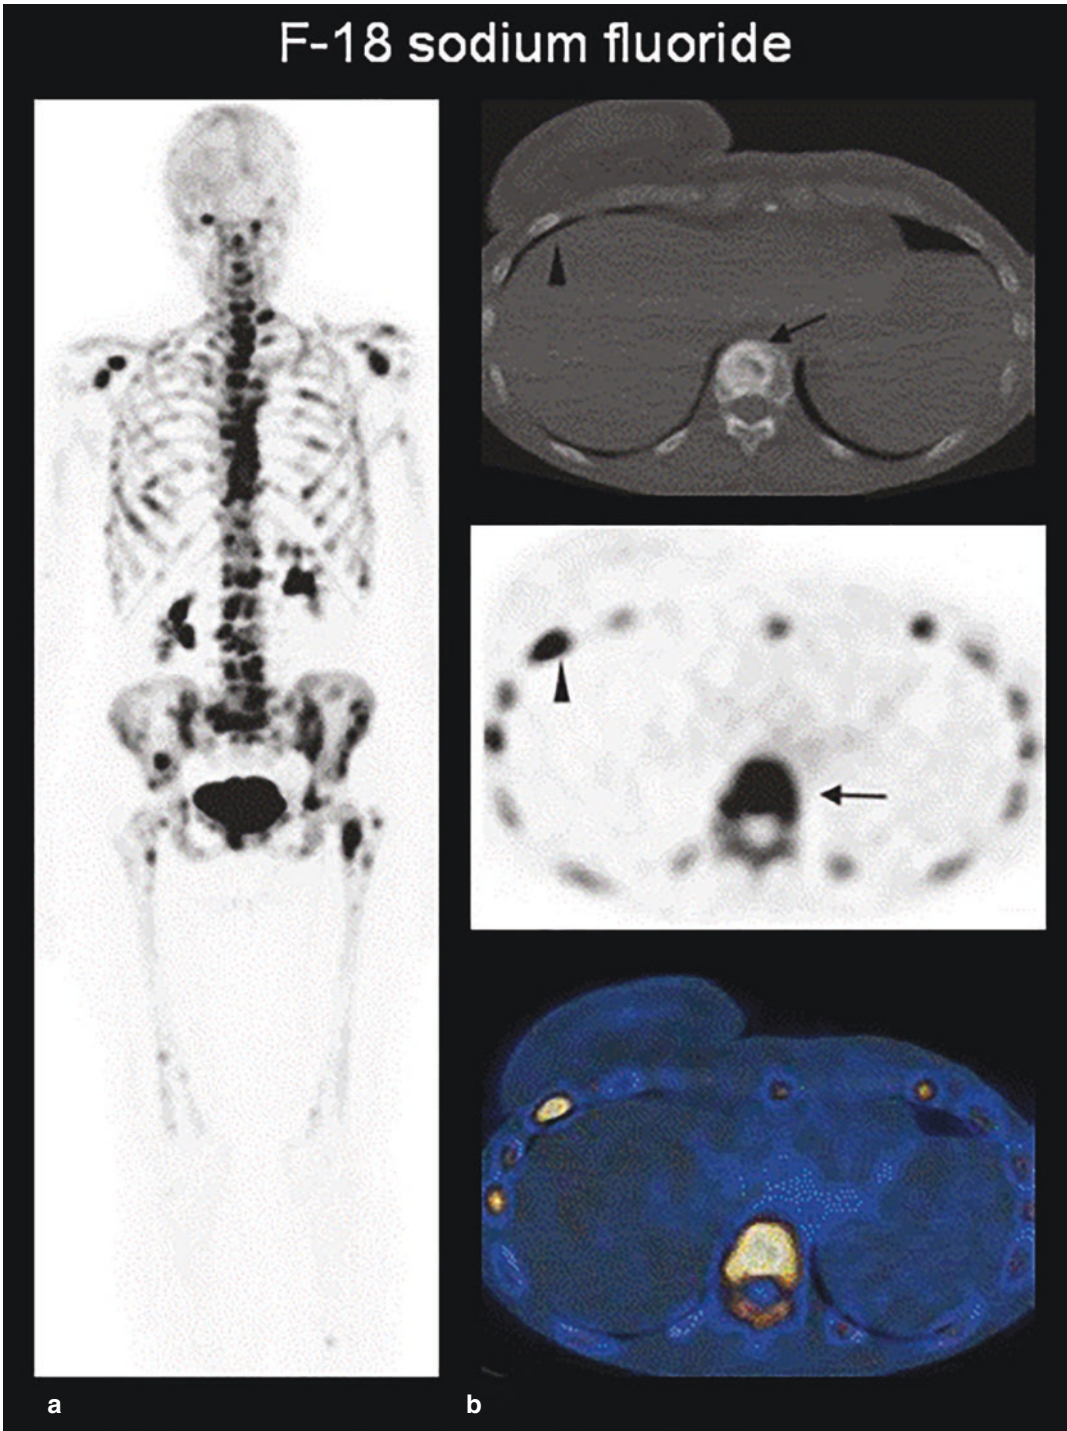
F-18 sodium fluoride PET/CT whole-body MIP (a) and selected transaxial CT, PET, and PET/CT fusion images of the chest (b) showing increased uptake at
